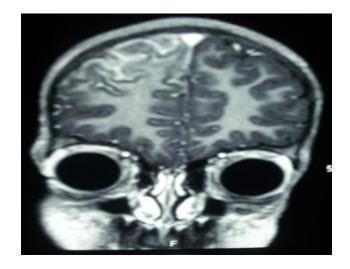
MRI Brain Coronal image showing increased intensity signals right frontoparietal area.
